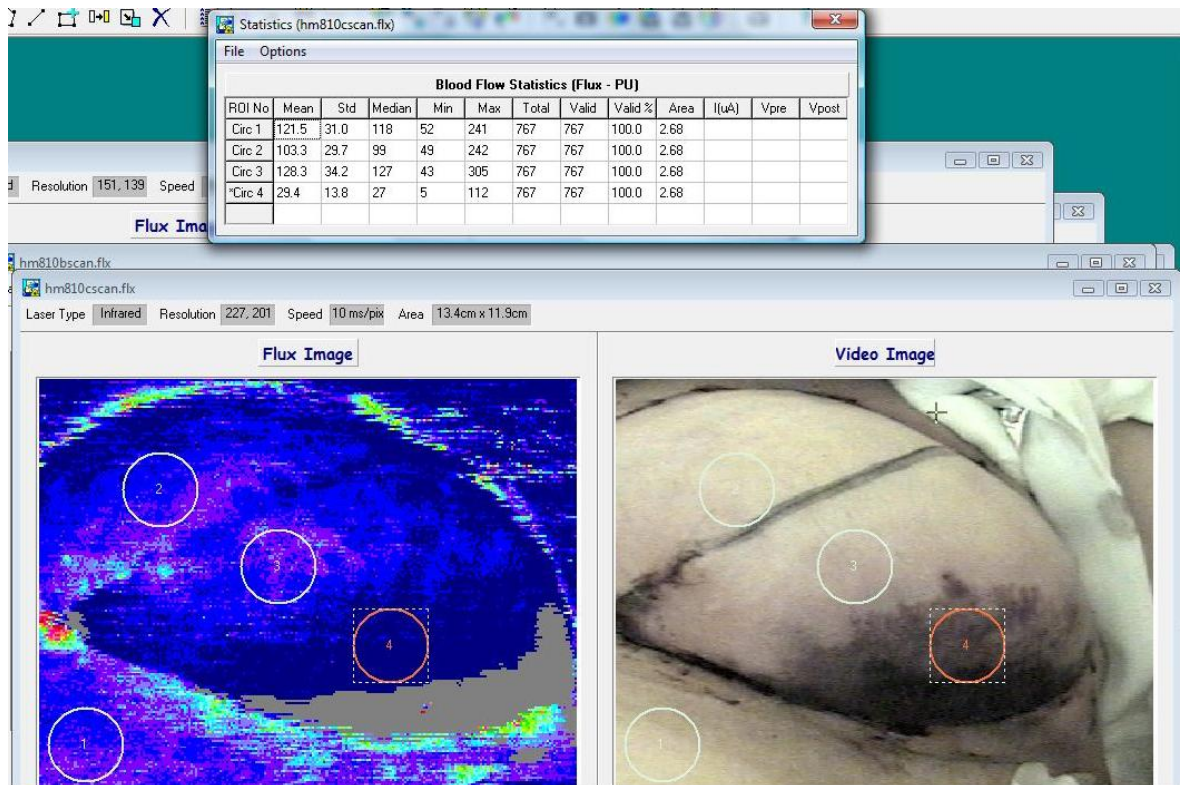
Laser Doppler imaging of patient 4 from the side. Placement of circles over zones (see flux image on left only), and baseline from patients abdomen.
